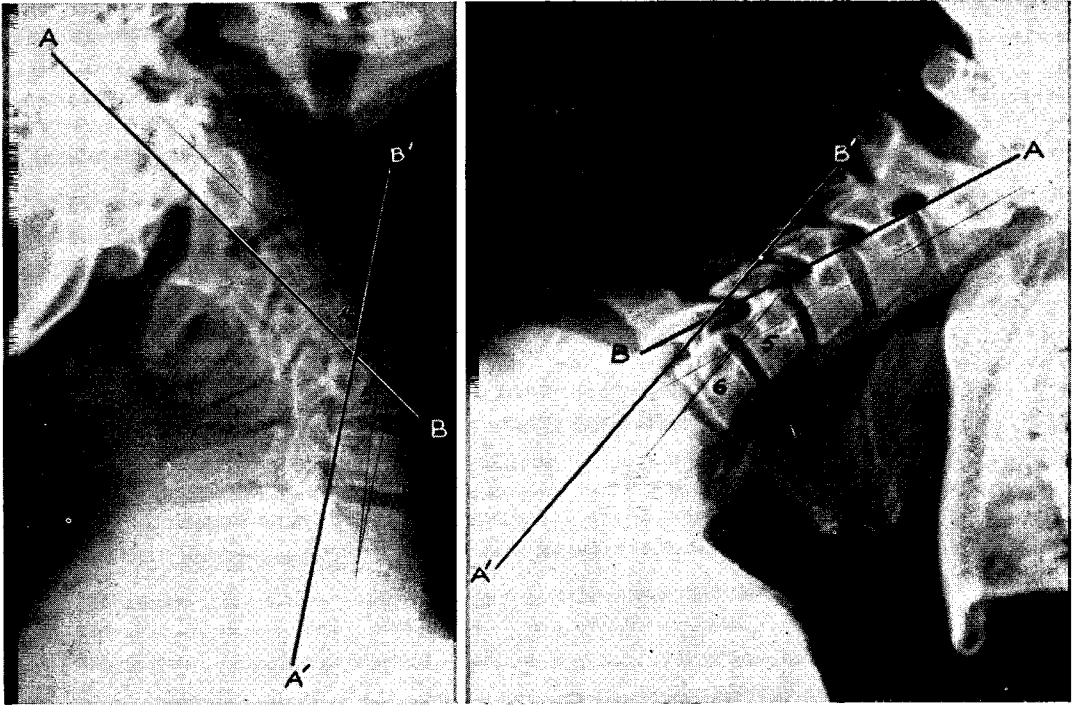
Roentgen films of a cervical spine in hyperextension (*left*) and flexion (*right*). Point of intersection of lines AB and A'B' indicates level of maximum stress and strain.
